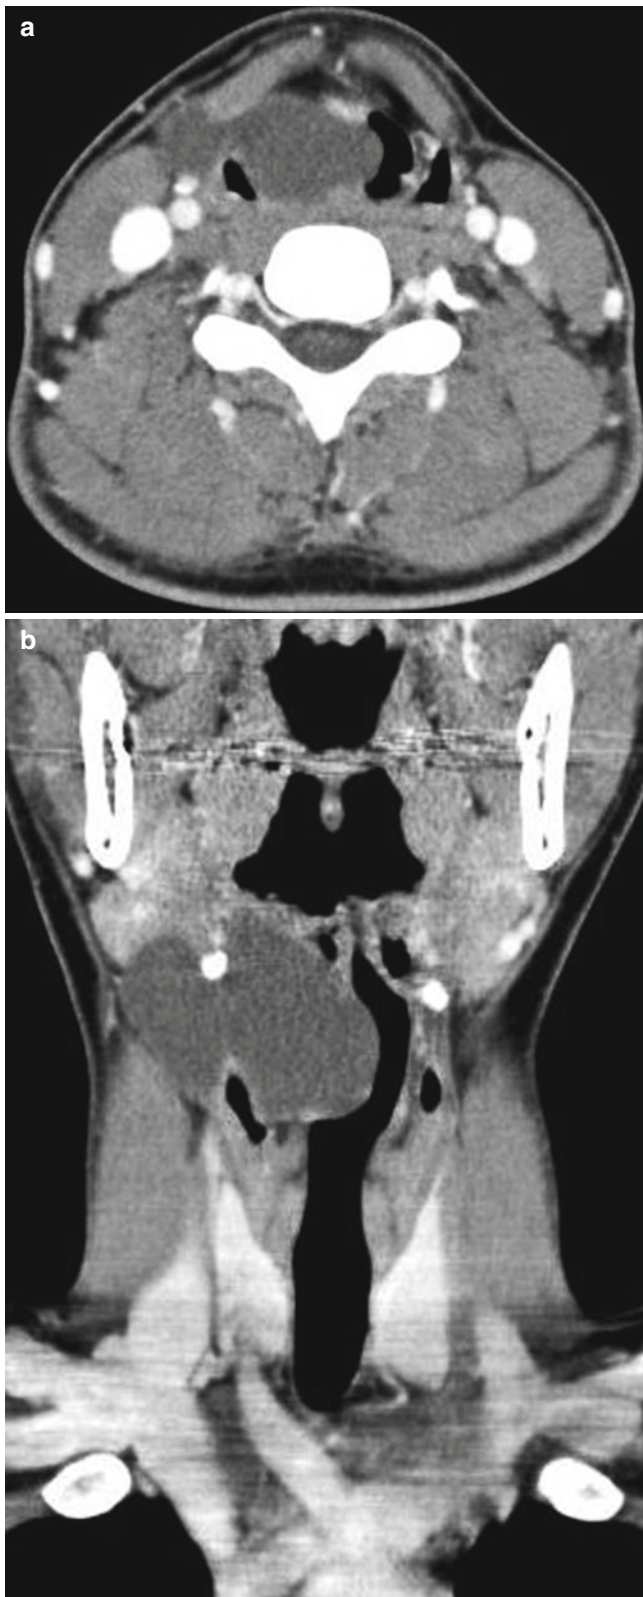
Laryngocele in a 15-year-old boy. (a) Axial CT scan shows a bilobed cystic mass in the right lateral wall of the larynx. (b) Coronal reformatted CT scan shows a bilobed thin-walled cyst arising from the right lateral wall of the supraglottic larynx and extending into paralaryngeal soft tissue
